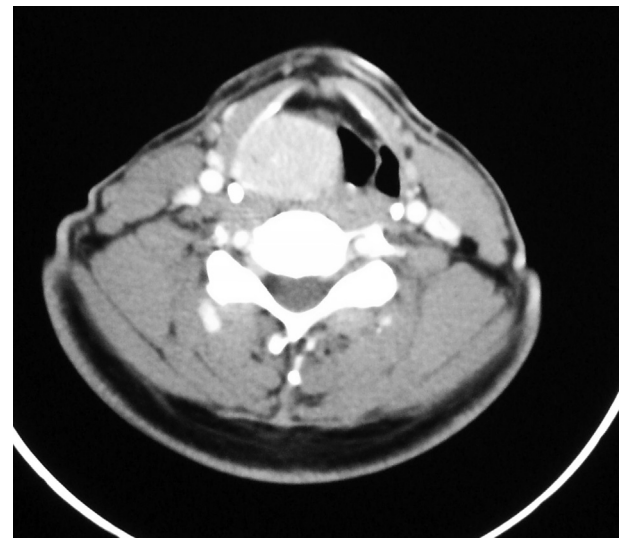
CT contrast showing a well defined homogenous and intensely enhancing mass in the right aryepiglottic fold bulging into right pyriform fossa. There is no erosion of thyroid cartilage.
